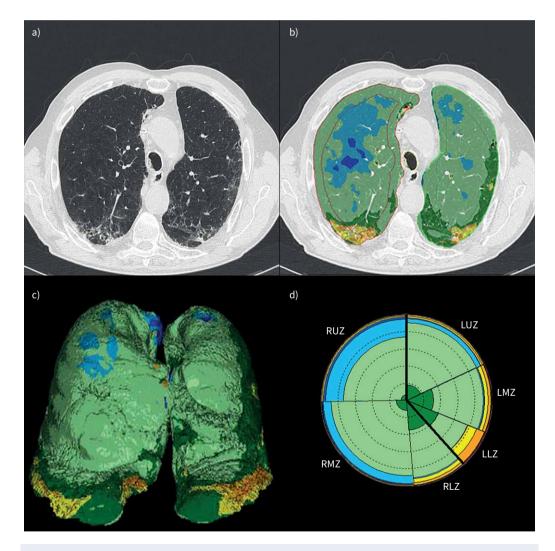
a) Axial computed tomography (CT) slice; b) axial Computer-Aided Lung Informatics for Pathology Evaluation and Rating (CALIPER)-derived colour image overlays, c) three-dimensional CALIPER anterior view rendering of the lungs displaying different parenchymal patterns (colour-coded), and d) a glyph that provides summary of distribution for CT patterns as various colours. Dark green: normal lung (in this subject, 18.1% of the total lung volume); light green: mild LAAs (63.4%); light blue: moderate low-attenuation areas (LAAs) (8.6%); dark blue: severe LAAs (1.2%); yellow: ground-glass opacity (2.5%); orange: reticular pattern (2.3%); red: honeycombing (0.3%). LLZ: left lower zone; LMZ: left middle zone; LUZ: left upper zone; RLZ: right lower zone; RMZ: right middle zone; RUZ: right upper zone.
